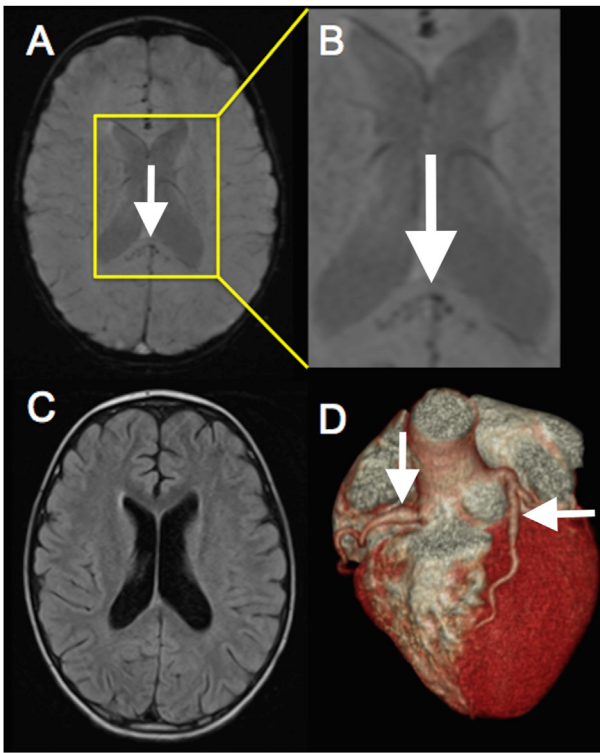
Critical illness-associated brain microhemorrhages in a child with multisystem inflammatory syndrome associated with coronavirus disease 2019. Brain magnetic resonance imaging showed microhemorrhages in the splenium of the corpus callosum as seen on susceptibility-weighted imaging (arrows in A and B), without abnormalities seen on other sequences. (C). A coronary computed tomography angiogram showed coronary arteries ectasia (arrows in D).
